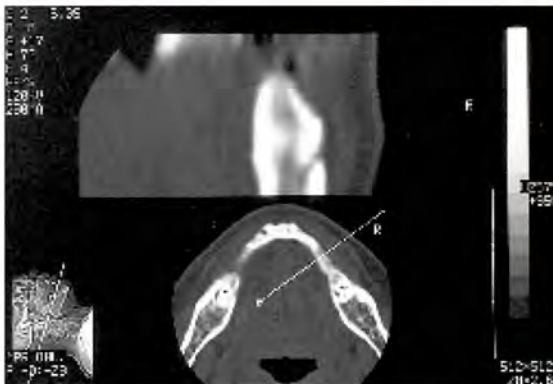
This computed tomography scan shows the precise location and direction of the mandibular canal.
